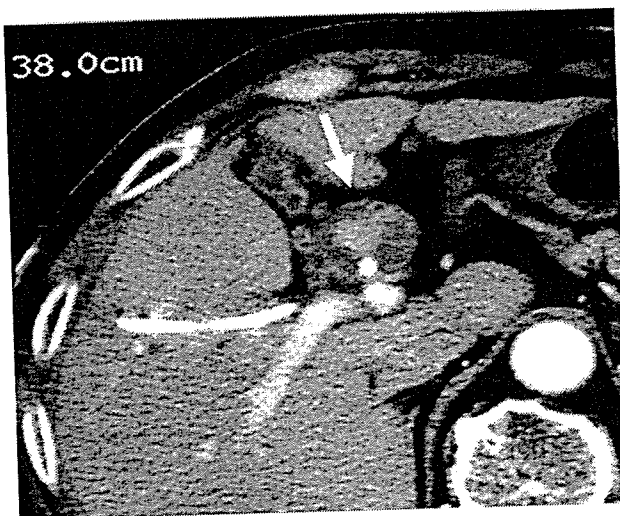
Abdominal computed tomography. A mass (*arrow*) is seen in the left intrahepatic bile duct into the common bile duct
